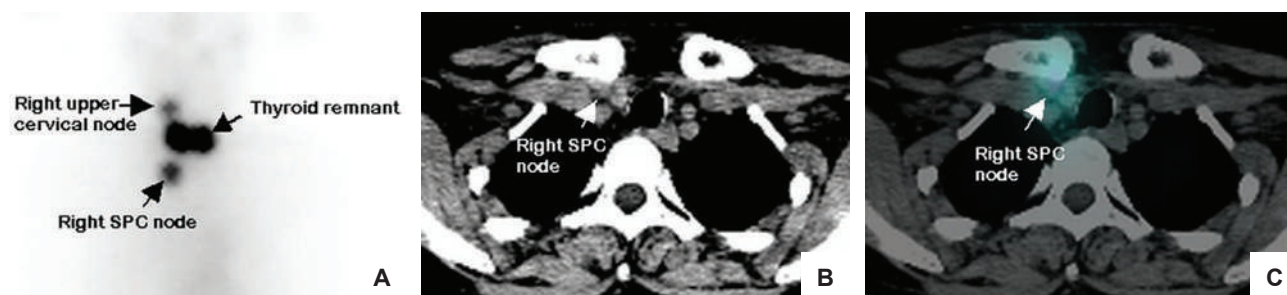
(A) Postoperative I-131 scan revealed two radioiodine-avid right upper cervical and supraclavicular (SPC) node metastases. The right SPC node was demonstrated in these (B) CT scan and (C) SPECT images.
